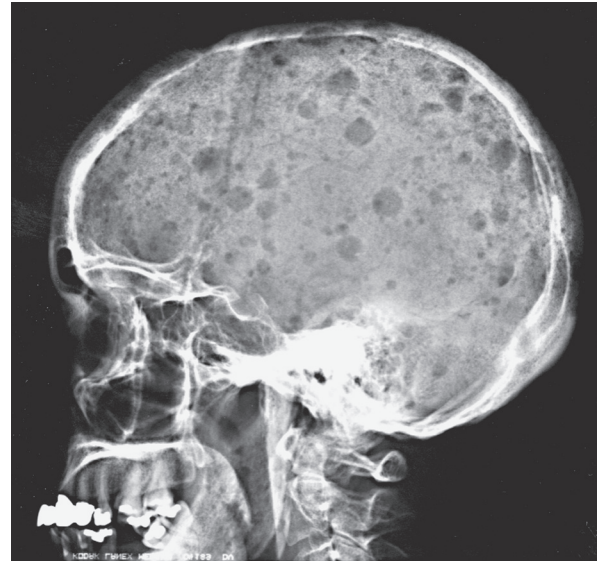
Calvarial radiograph from a patient with multiple myeloma.
